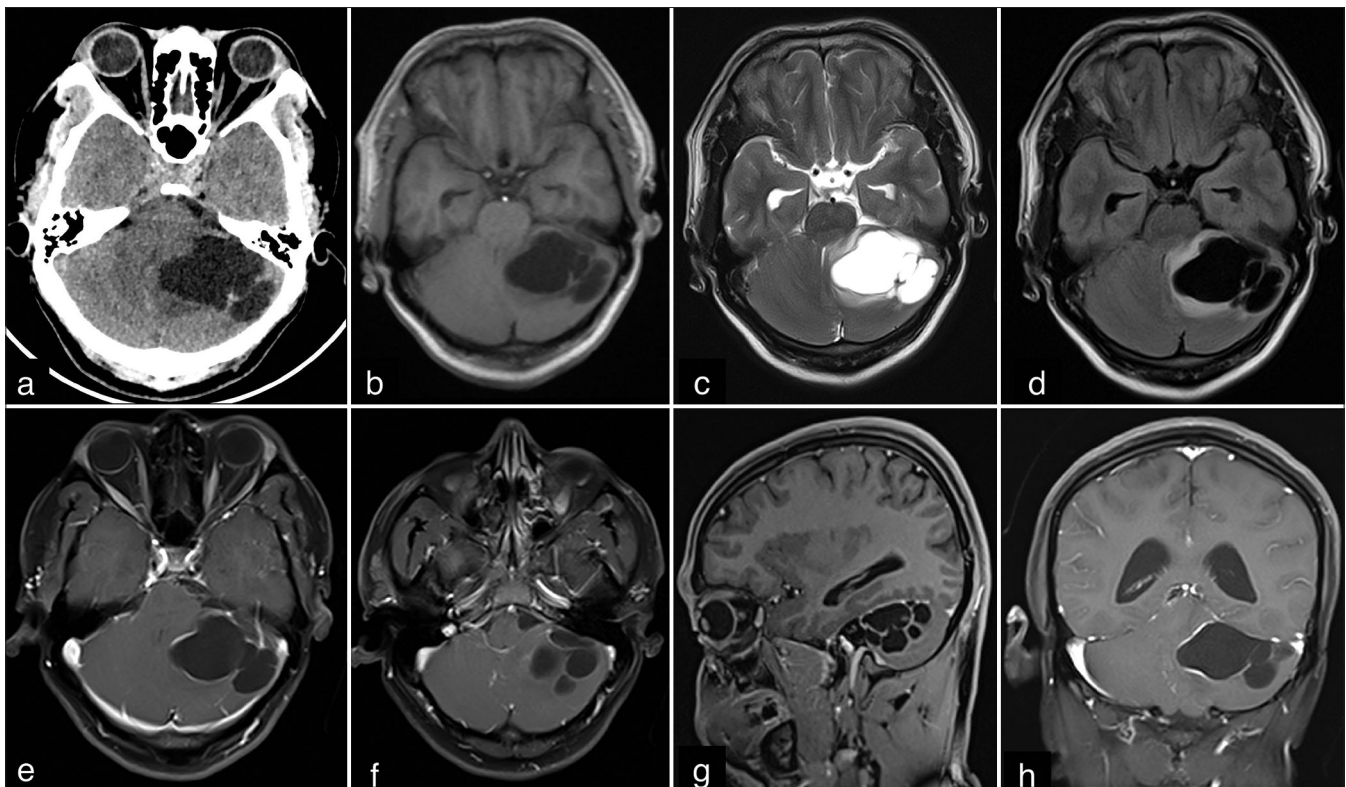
(a) Noncontrast computed tomography head showing a hypodense lesion in left cerebellum, (b-d) Axial magnetic resonance imaging (MRI) T1-weighted sequence showing a hypointense lesion involving left cerebellar hemisphere with hyperintense signal on T2-weighted sequences matching that of cerebrospinal fluid along with a fluid-attenuated inversion recovery hypointensity with surrounding hyperintense signal suggestive of perilesional edema, (e and f) Axial T1-weighted image with contrast sequences, (g) Sagittal and (h) coronal T1-weighted sequences with contrast depicting a ring enhancing lesion in the left cerebellum.
